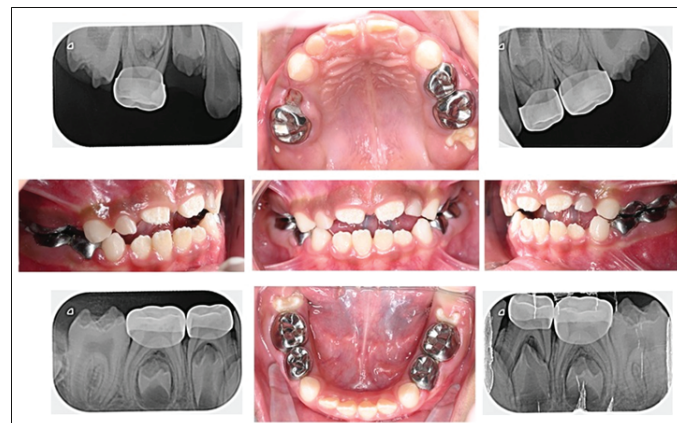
Postoperative photographs and radiographs
